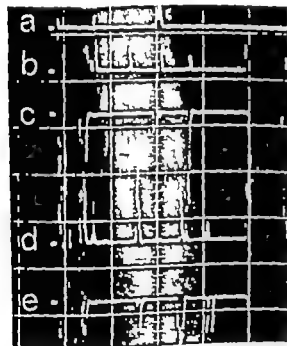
The A-scan registrations photographed on the same picture. The order of the echocardiograms from the top: a) the midline control by the transmission method, b) the midline echo and the body echoes of the lateral ventricles on the right-to-left tracing, c) the midline echo and the body echoes of the contralateral ventricles on the left-to-right tracing, d) the right-to-left tracing showing the temporal horn echoes as the last echoes before the end echo, e) the same as d) on the left-to-right tracing, the echoes on both sides of the saddle of the screen obviously originate in the circumperitumular antenna.
